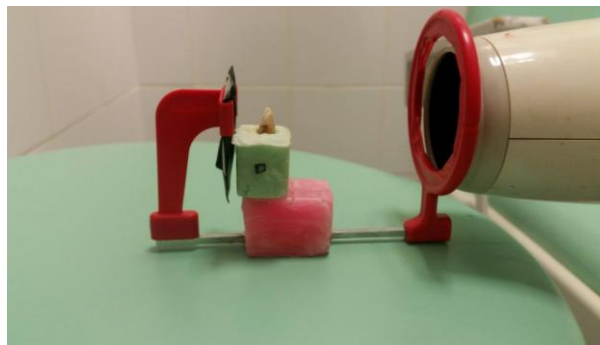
Apparatus used for radiography standardization
